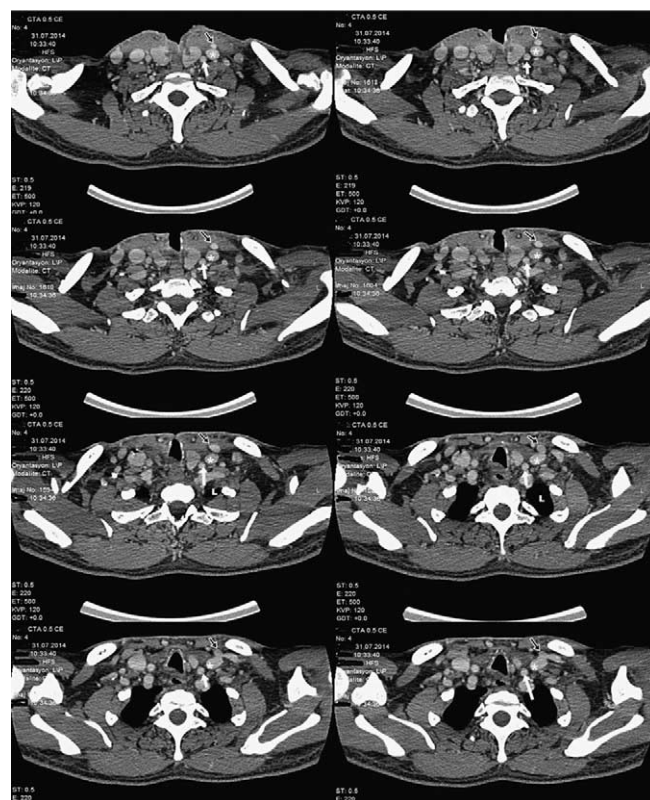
Axial postoperatively taken computed tomography angiography scans. Black arrows indicate left duplication of the jugular vein; white arrows, left common carotid; white asterisks, internal jugular vein.
